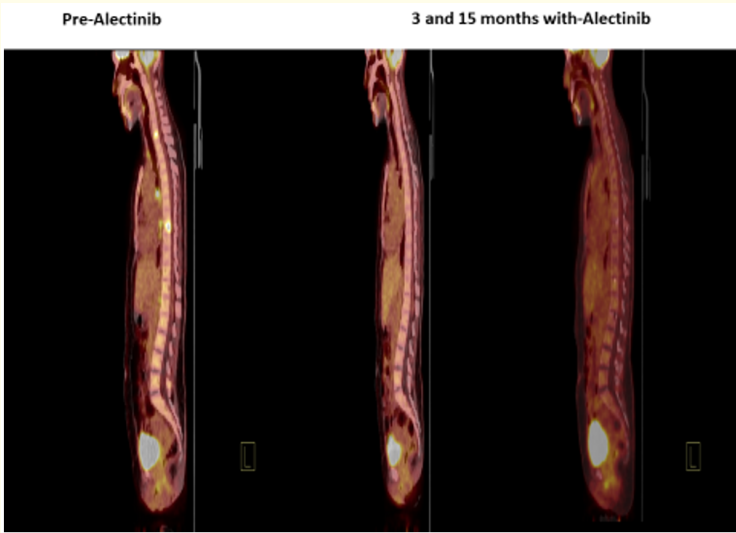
Complete tumor response et the 36 years old women after 3 and 15 months treatment with alectinib-PET/CT sagittal view.
